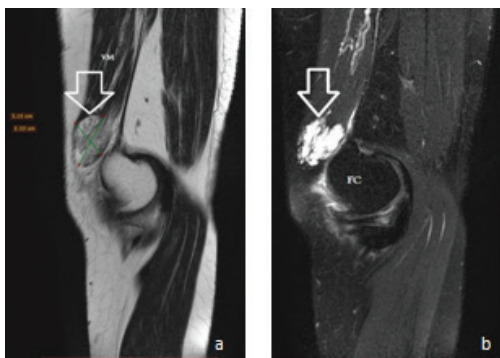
Sagittal section of the affected leg. (a) T2W image shows the lesion of medium to high intensity at the lower end of the VM (inverted arrow). (b) T2W with fat saturation MRI image reveals well localized pathology (white-inverted arrow) above the femoral condyle condyle.
